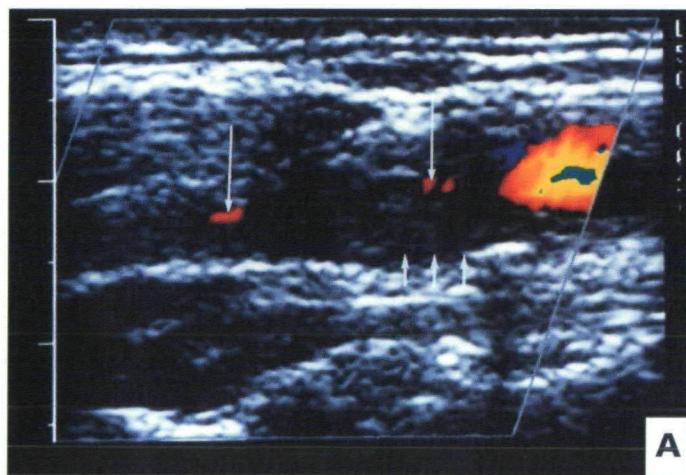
(A) The lumen of the internal carotid artery (short arrows) is filled with echo-poor thrombus but some flow is demonstrated on colour Doppler ultrasound (long arrows) with optimized flow settings, indicating a near occlusion. (B) Angiography confirms a short patent segment of internal carotid artery (arrow).
